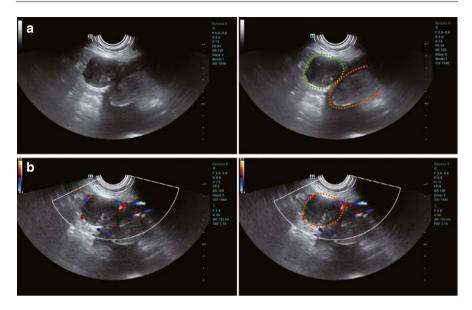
(a) Red degeneration of the fibroid: A subserosal fibroid in the lateral wall of the uterus with decreased echogenicity internally and no attenuation of echogenicity in the posterior area. The placenta is outlined in orange; the fibroid is circled in green. (b) Red degeneration of the fibroid: Color Doppler ultrasound shows no significant blood flow within the fibroid (the patient was pregnant and experienced significant abdominal pain). The fibroid is circled in orange
